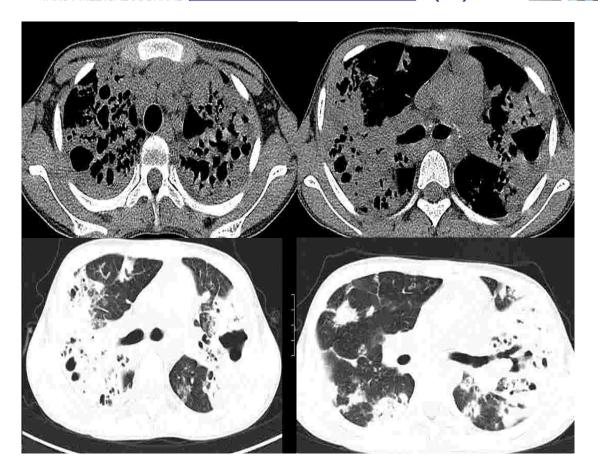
Computed tomography of the lungs and mediastinum. Bilateral caseous pneumonia (complication of tuberculosis of the intrathoracic lymph nodes).
